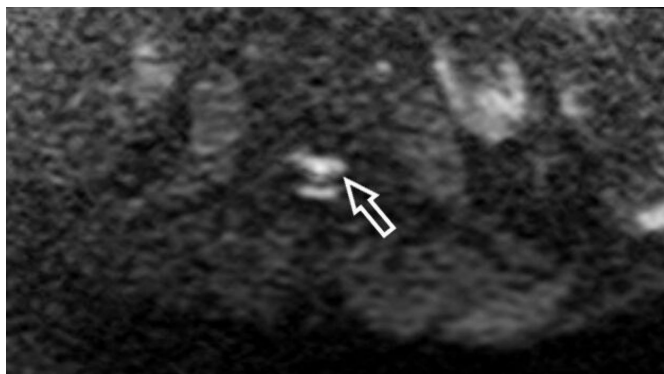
Diffusion-weighted imaging (DWI) at T4 level showing diffusion restriction (hyperintense signal).
